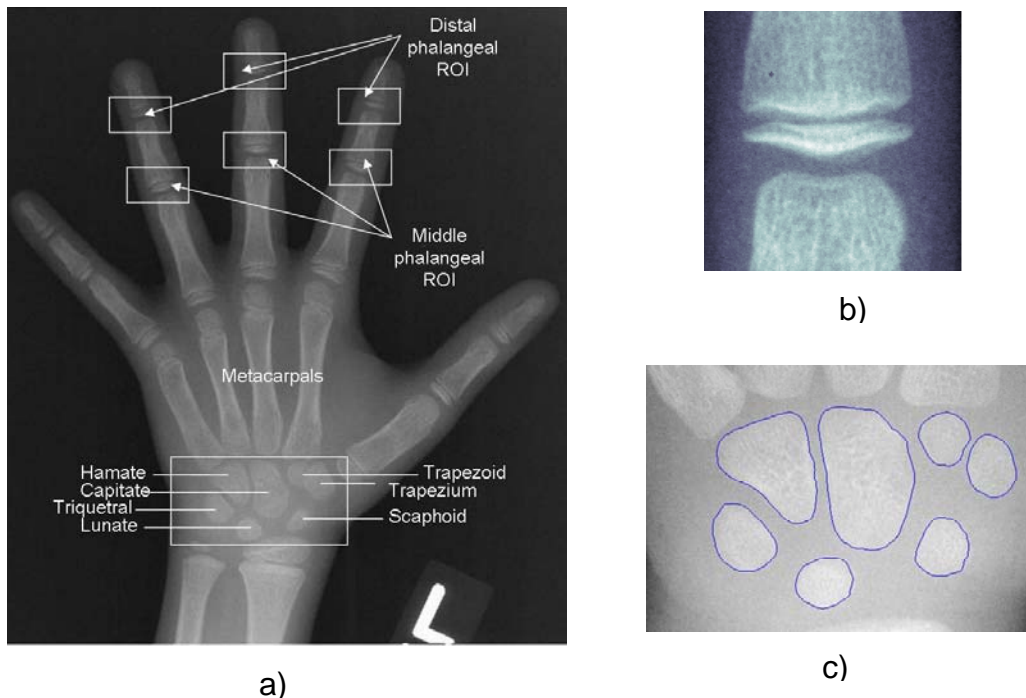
An example of hand image radiograph with superimposed regions of interest: a) a hand image with seven ROIs, b) the phalangeal region of interest (PROI), c) the carpal bones region.
